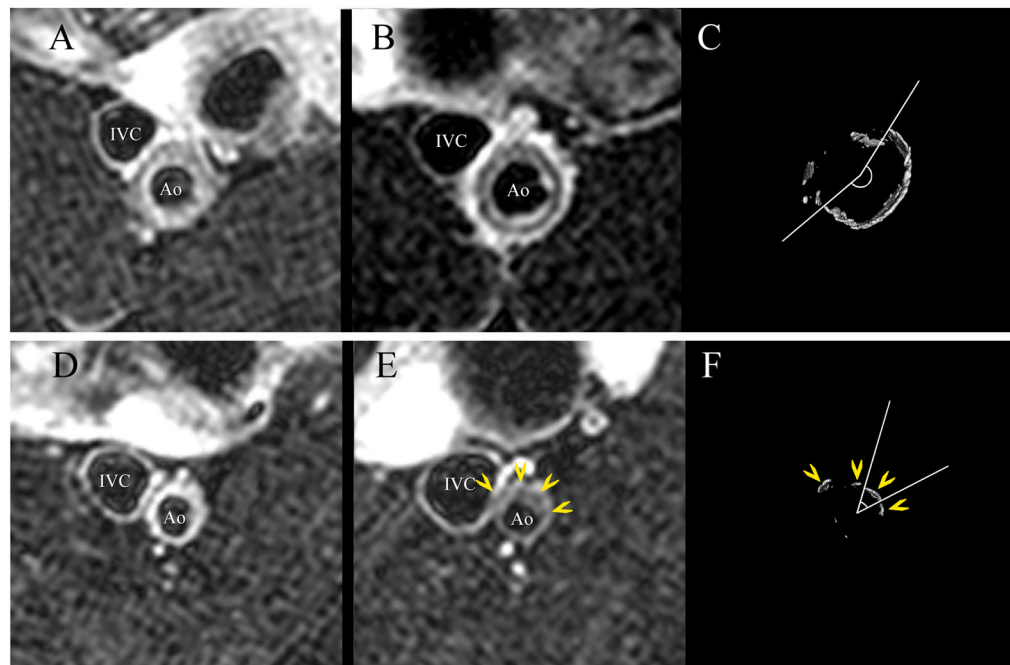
Representative axial MRI and μ CT images of the abdominal aorta. Raloxifene treatment (upper panels) resulted in a ring of calcification seen as low signal intensity within the vessel wall in the T2-weighted image (B) and confirmed in the matching μ CT image (C). The distribution of calcification in the control OVX aortas was less organized and more nodular (E, F); yellow arrowheads identify matching calcifications. Corresponding pre-treatment MR images are seen in panels (A) and (D). The largest arc of calcification was measured for each μ CT image (C, F). Ao: aorta; IVC: inferior vena cava.
